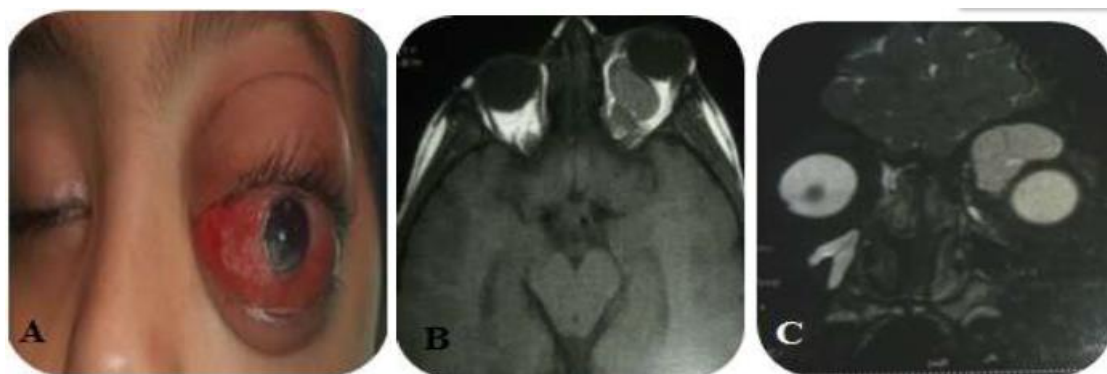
Preoperative clinical appearance of malignant left exophthalmos following intra-tumoral bleeding. Cerebral MRI in axial and coronal section in flare and T2 in fat suppression shows several intra conical cystic logettes filled with injured blood.
